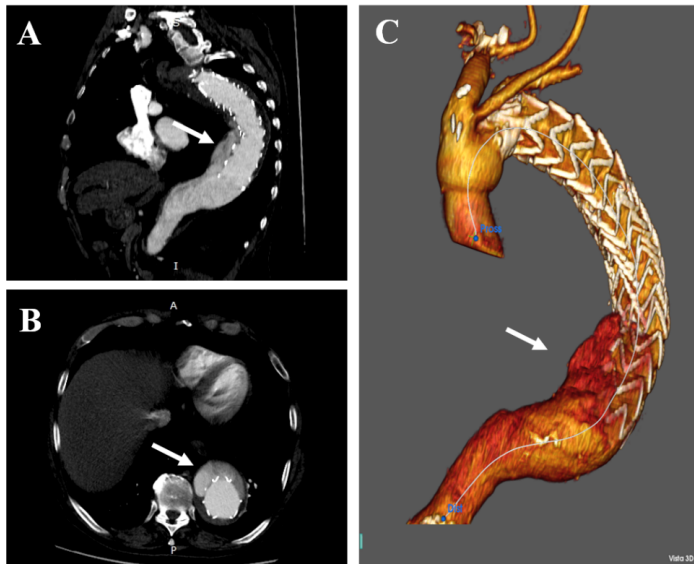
Preoperative CT-scan. A-B: Multi-Planar Reconstruction; C: 3-D Reconstruction. The arrows show the type 1B distal endoleak.
